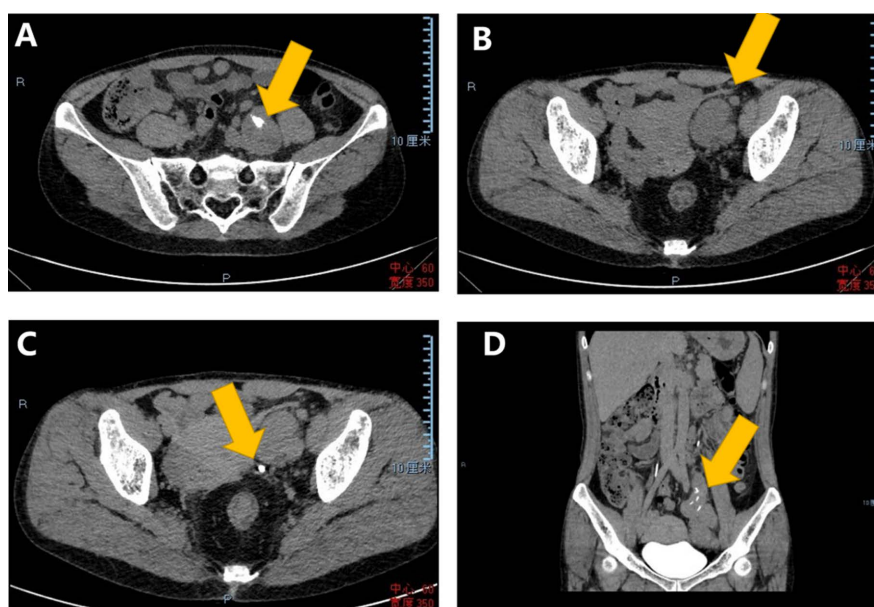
Figure (A)/(B) shows CT flat sweeping the left pelvic retroperitoneal capsule, with calcifications with a maximum diameter of 55*49 mm calcification. Figure (C) shows the left ureter passed by the right posterior mass and displaced to the midline and front, with no signs of expansion and stricture. The (D) plot shows the close adhesion of the left internal iliac vessel to the mass.
